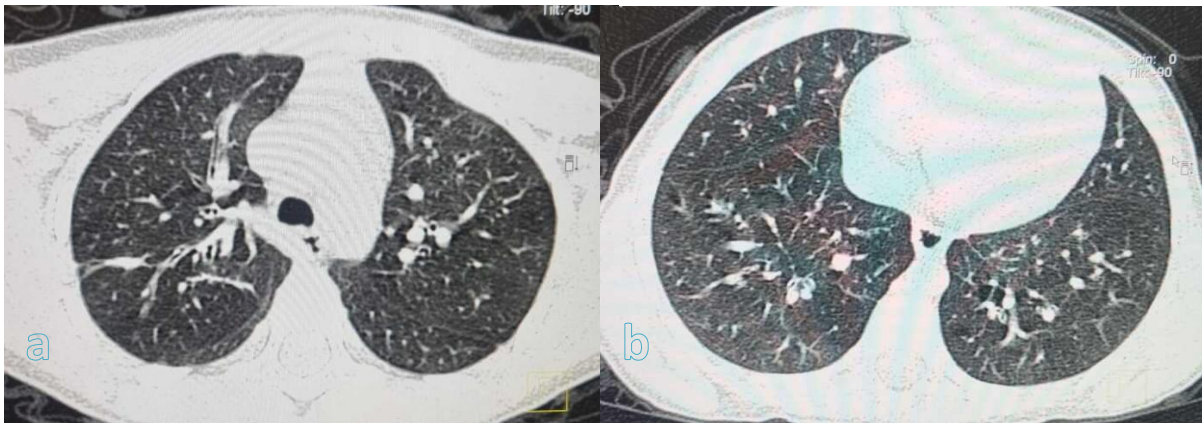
(a,b). The chest CT scan performed one month after the accident showing the disappearance of pneumothorax and pneumatoceles
